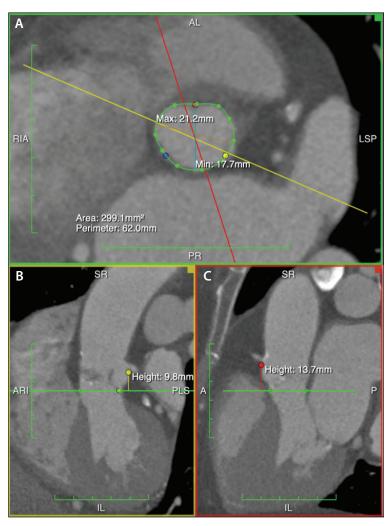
Angio CT measurements: annulus of 62 mm (A), left main takeoff of 9.8 mm (B), right coronary takeoff of 13.7 mm (C).
